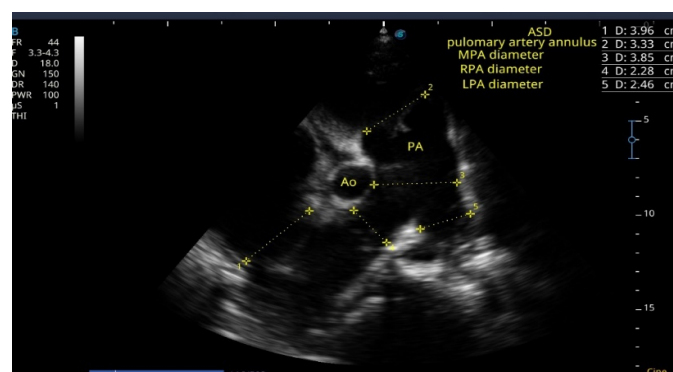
Pulmonary Artery from Parasternal Short Axis View
